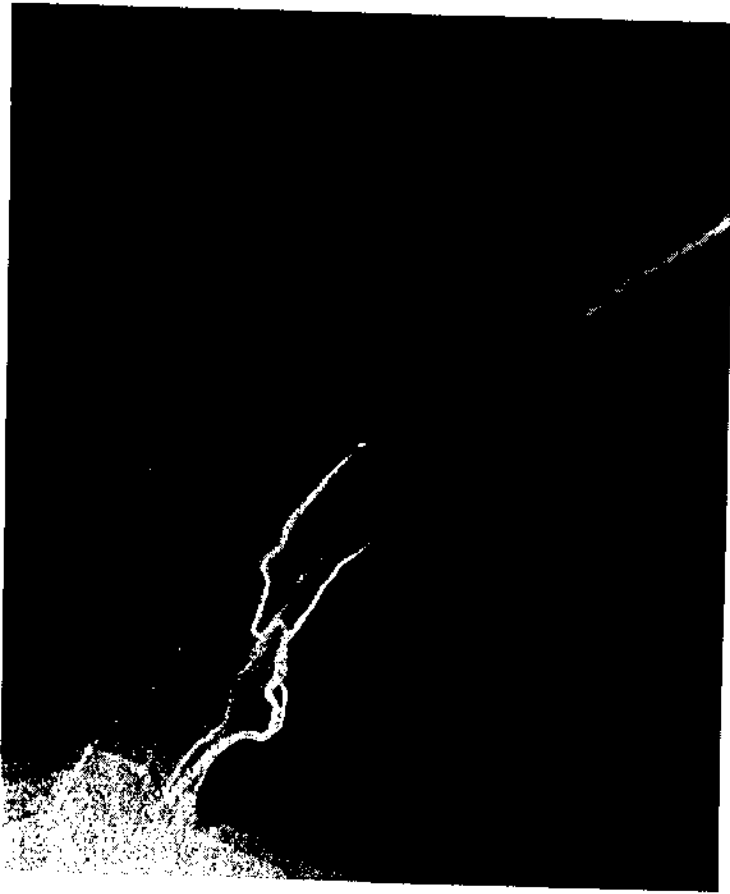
Deer 118 (antler) on 19 November 1982 in mid-antler development: a sequence of radiographs taken 10 (*upper left*), 11 (*upper right*), and 12 seconds (*lower*) after injection.
